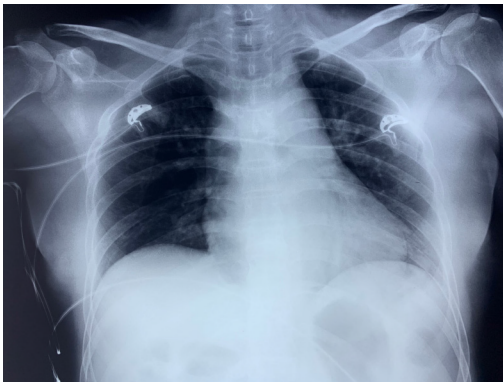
Bedside chest X-ray result after the patient had been transferred to the urosurgery ward. No evidence of pneumothorax or rib injury was found after the lung dilation.
